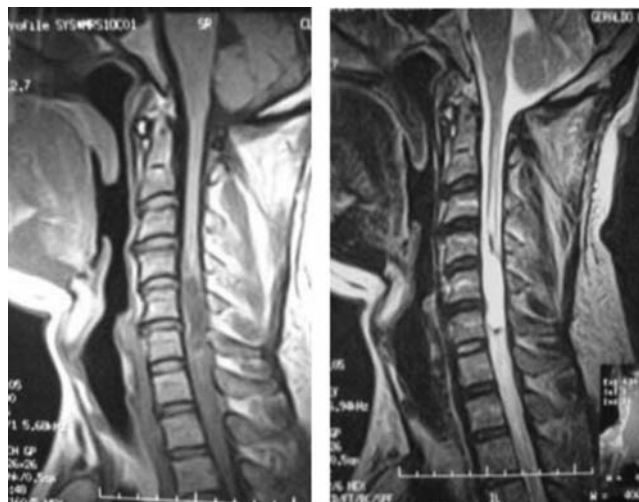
Pre-operative cervical spine magnetic resonance (Sagittal T1- and T2-weighted images).
